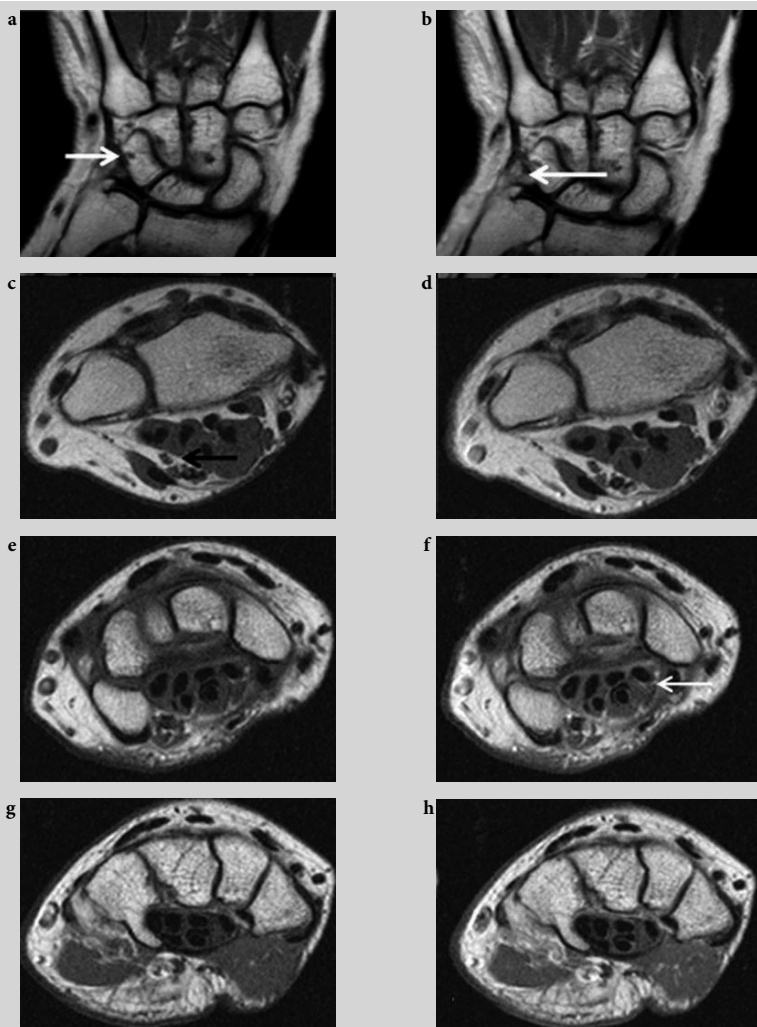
Magnetic resonance imaging (MRI) of the wrist of patient with early rheumatoid arthritis after treatment with disease-modifying antirheumatic drug. Same patient as Figure 6.1. T1-weighted MRI in the (a, b) coronal and (c–h) axial planes, before (left column) and after (right column) intravenous contrast injection. (c, d): Axial section through the distal radius and ulna. (e, f): A section through the proximal row of carpal bones. (g, h): A more distal section through the hook of the hamate. The flexor tenosynovitis (thin short arrow) and particularly the synovitis have decreased markedly compared to before treatment (Figure 6.1). The erosion in the triquetrum (short thick arrow) is still seen.
